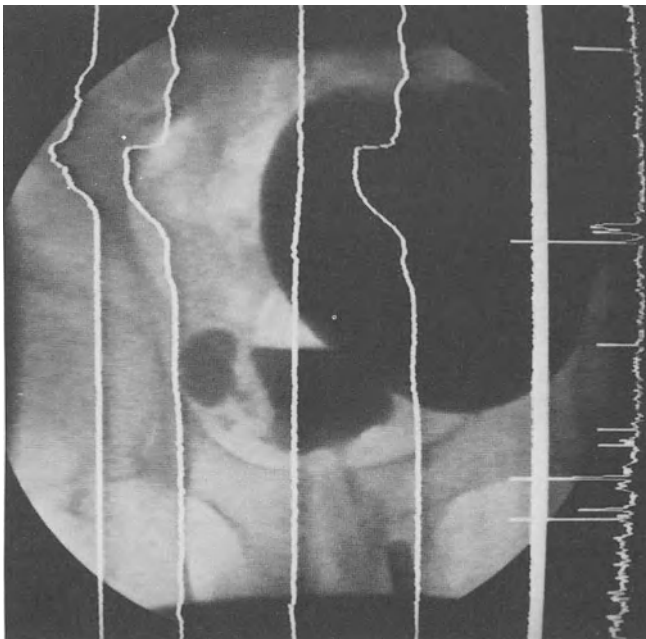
Synchronous uro-video-cystourethrography using an analogue to video converter with a digital output. The X-ray shows a bladder with one large and one small diverticulum. The urodynamic traces (from right to left) are flow, vesical pressure, abdominal pressure, detrusor pressure, a blank trace and on the right the integrated EMG. On attempting to void there is a slight elevation of detrusor pressure for a considerable time while the diverticulum fills up. Only then can the pressure rise further, the bladder neck opens and the flow starts.
